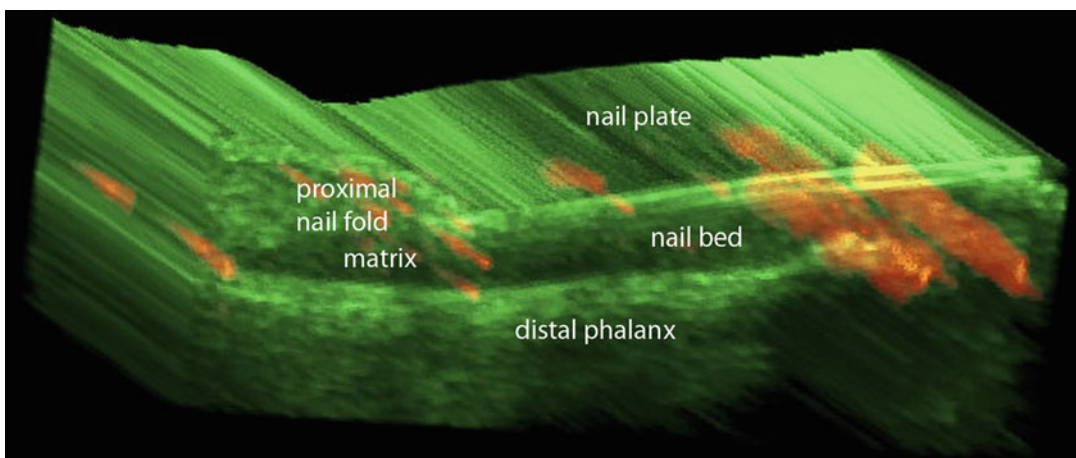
3D power Doppler reconstruction of the nail unit (longitudinal view) demonstrates the vascularity (*red color*) within the nail bed
